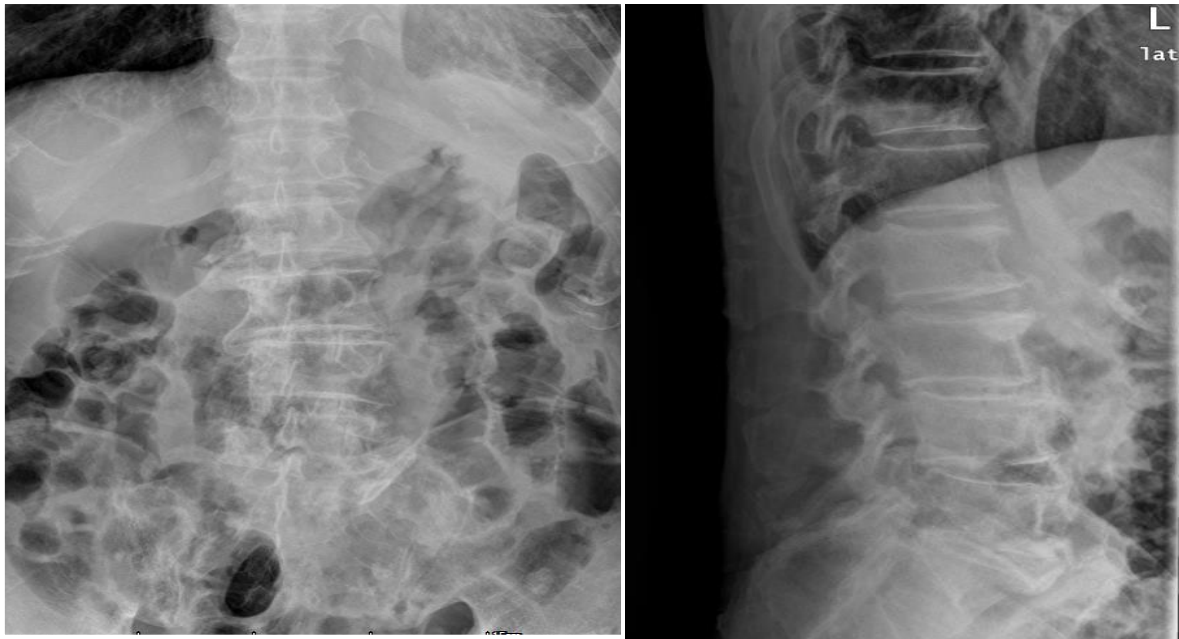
Pre-operative X-ray pictures
